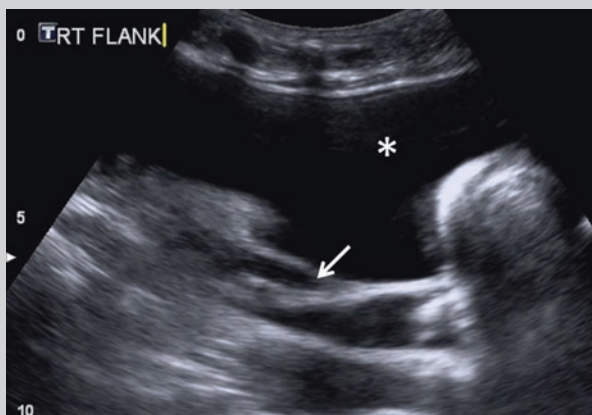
Ultrasound of the right flank demonstrating a deep pocket of fluid (*asterisk*) with some loops of bowel visualised deep in the abdomen (*arrow*)
